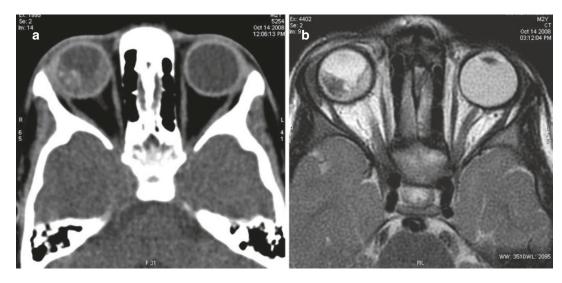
(a) Axial CT scan of the orbit showing a hyperdense mass in the temporal quadrant of the right eye. Multiple specks of calcification are seen within and associated retinal detachment. (b) Axial T2 weighted image
